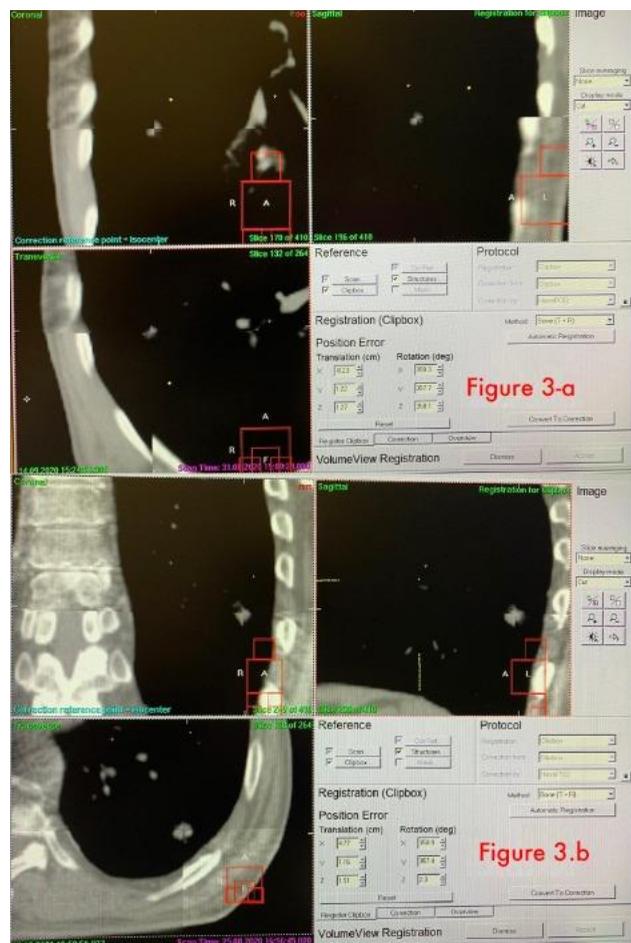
Comparing CT and CBCT with XVI
